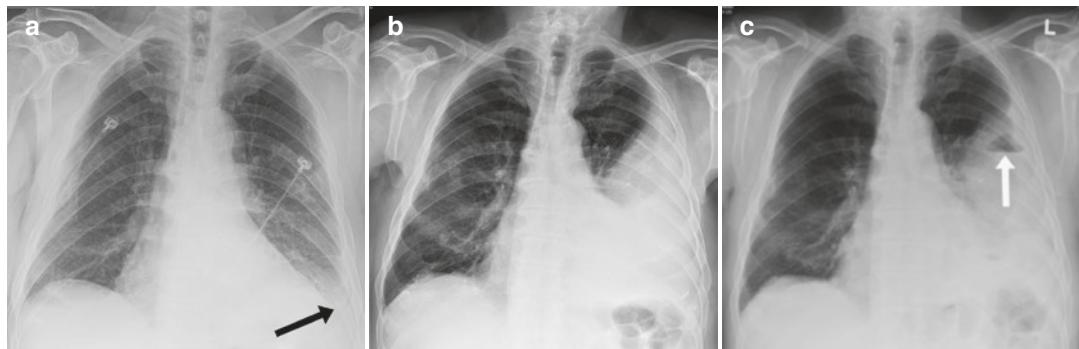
Serial radiographs in a 77-year-old man demonstrating evolution of empyema. AP radiograph at initial presentation (a) was reported as concerning for left lower lobe pneumonia. The presence of a pleural effusion was not discussed in the report but is suspected in retrospect due to increased density laterally (black arrow). The patient represented with pain at which time a pleural effusion was reported (b). However, the size of the effusion
